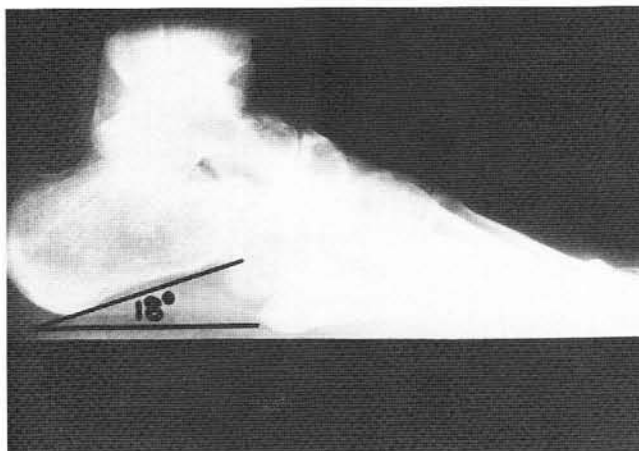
Preoperative lateral radiograph.
